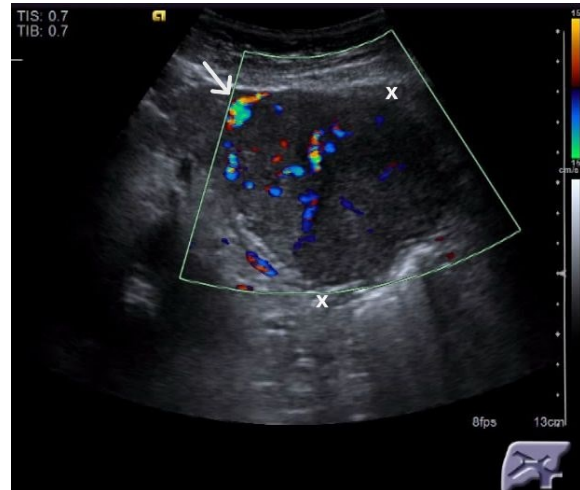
a.28. Isoechoic FNH – Power Doppler “spoke wheel” pattern. Feeding artery visible (arrow)
